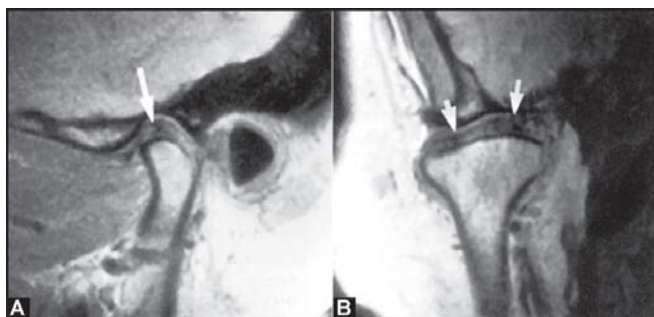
MRI of a normal TM joint A. Closed view showing the condyle and the temporal component. The biconcave disk is located with its posterior band over the condyle. B. Coronal image showing the osseous components and disk superior to the condyle
